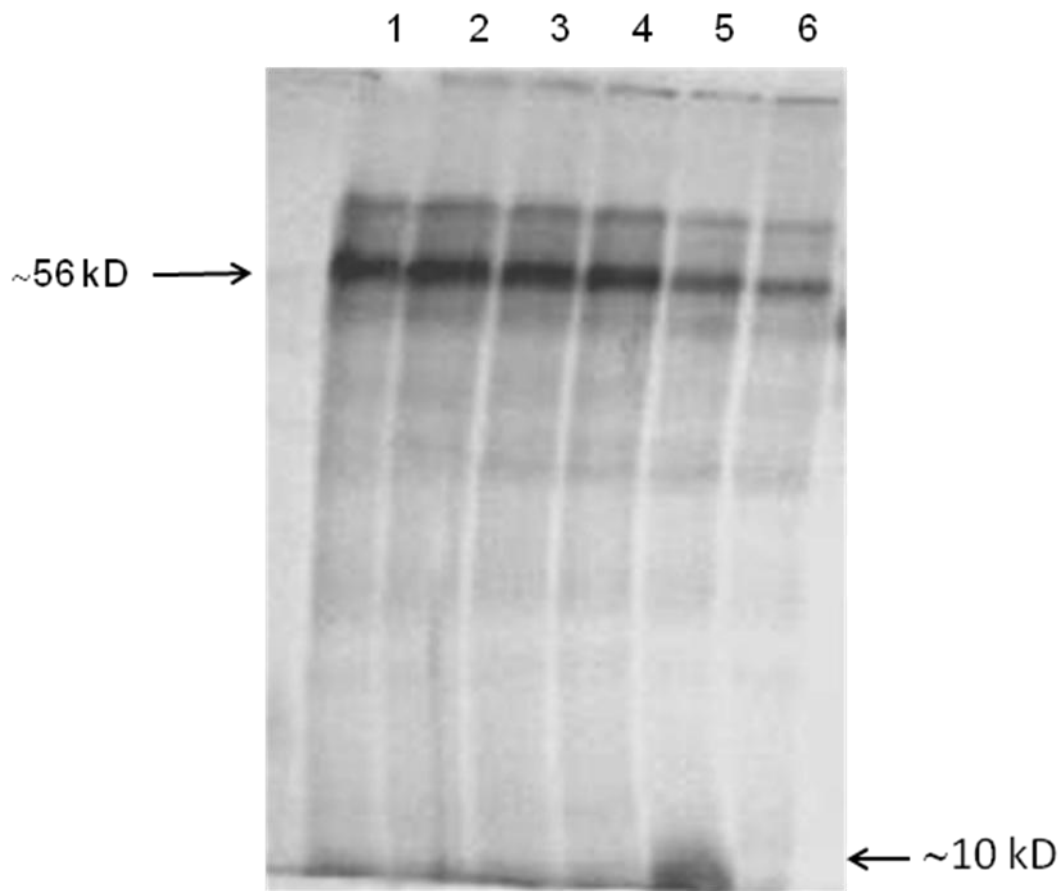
Polypeptides generated for fragment 2 of *BRCA1* exon 11. The fragments represent the amplified DNA fragments for CAM 1971 (lane 1), CAM 1972 (lane 2), CAM 1974 (lane 3), CAM 1975 (lane 4), CAM 1973 (lane 5) and CAM 1976 (lane 6). Translated polypeptides were separated on a 12% polyacrylamide gel and exposed overnight to an X-ray. A premature truncated polypeptide of ~10 kD visible for CAM 1973 in lane 5 is indicated by the arrow.
